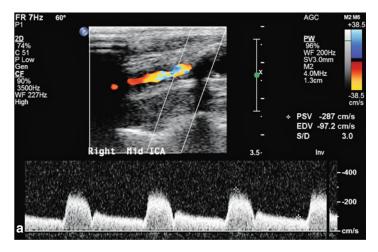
Stenting of a lesion in the proximal internal carotid. (a) Initial duplex ultrasound showing a stenosis in the internal carotid artery with a peak systolic velocity (PSV) of 287 cm/s and end diastolic velocity (EDV) of 97 cm/s. (b) Digital subtraction angiogram of the carotid artery demonstrating the stenosis in the proximal internal carotid artery with an ulceration just distal to the carotid bulb (black arrow). (c) Digital subtraction angiogram after placement of a stent from the common carotid artery to the internal carotid artery (white arrows). (d) Follow-up duplex ultrasound demonstrating markedly lower velocities after stenting (PSV 64.7 cm/s, EDV 21.2 cm/s)
